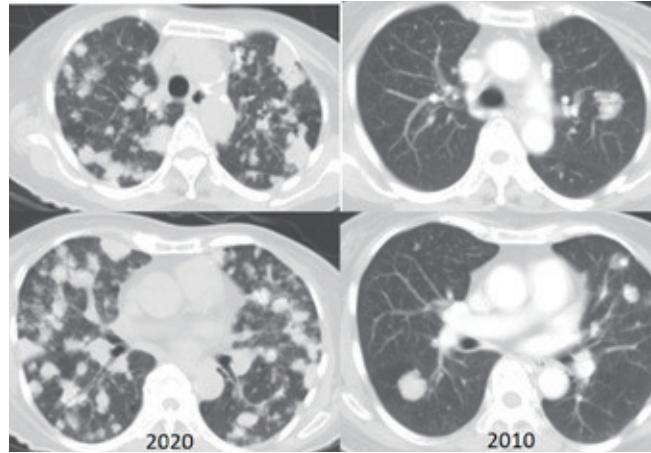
Comparison of CT thorax in 2010 and 2020
